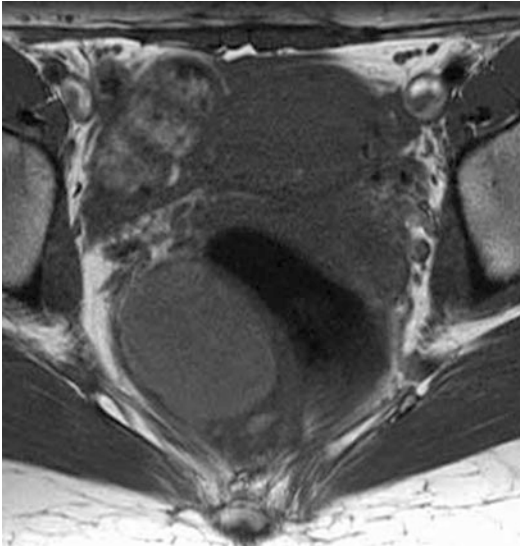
Epidermoid cyst on T1 axial and T2 sagittal sections on magnetic resonance imaging
